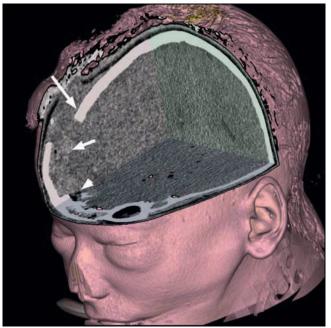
Volume-rendered multi-detector row CT images in a patient with a blunt high velocity trauma to the head. a Volume-rendering reconstruction with a high threshold for osseous depiction shows a depressed fracture of the skull accompanied by facial fractures (arrows). b Volume-rendering reconstruction with a low soft tissue threshold and a cut through the brain demonstrates a bleeding into the frontal lobe and some air bubbles indicating an open fracture
